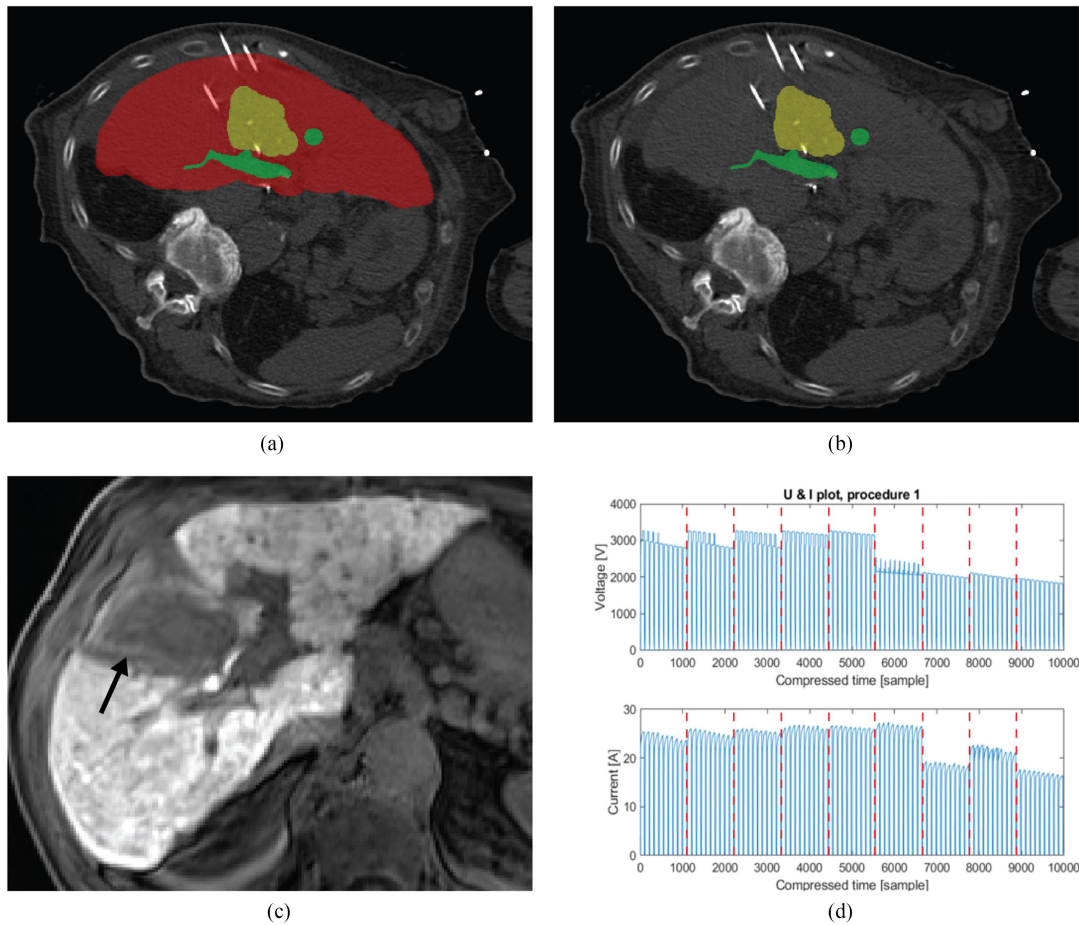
An example of tissue segmentation, electrode placement and follow-up imaging for one of the reconstructed cases (case P14 in Table E4 in supplementary materials). In this particular case, the tumor was very large, therefore two consecutive sessions were performed with 2 cm electrode retraction in between sessions. A) Tissue segmentation overlay on pre-interventional CECT (yellow – tumor, green – vessels, red – liver parenchyma). B) Native interventional CT with visible needle electrode positions. C) Seven week follow-up late phase T1W MRI. Ablation zone is visible as hypo-enhanced region with a hyper-intense rim (arrow). D) An example of voltage and electric current measurements recovered from NanoKnife device. Nine electrode pairs were used in this case with 100 pulses delivered to each pair in each session. Only the first 10 pulses of each pair are shown to highlight the difference in voltage magnitude applied to different pairs – there was no voltage decrease visible in the subsequent 90 pulses. Electrode pairs are separated with dashed lines.
